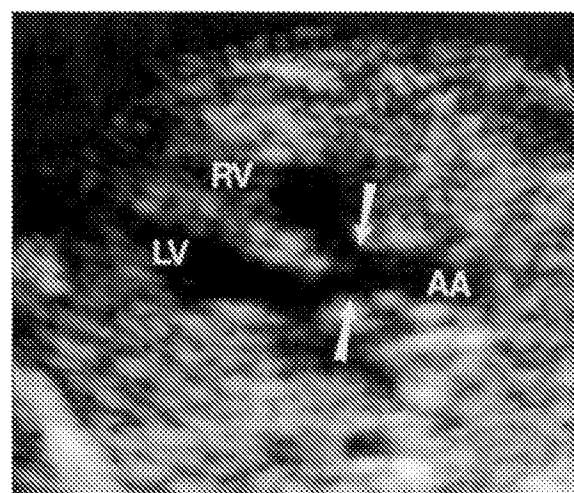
Tetralogy of Fallot in fetus at 21 weeks gestational age; fetus is supine and in vertex position. Transverse sonogram of chest shows overriding aorta (arrows) that originates from both left and right ventricles. LV = left ventricle, RV = right ventricle, AA = ascending aorta.
